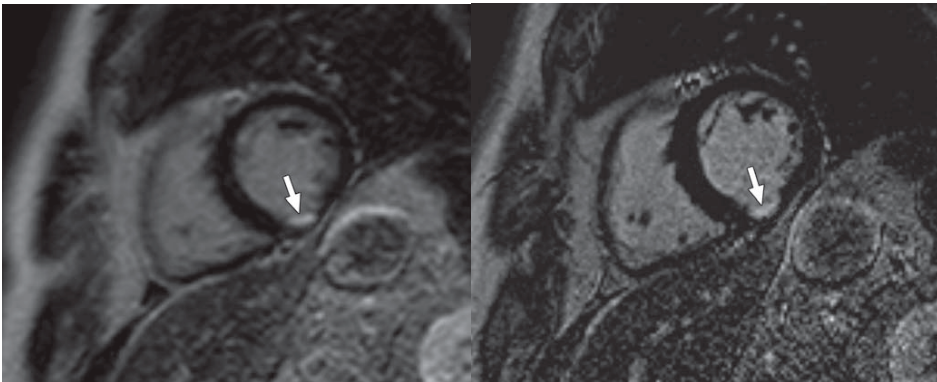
61-year-old man with myocardial infarction in inferior segment after occlusion of right coronary artery. (A) Breath-hold 3D gradient-echo inversion-recovery delayed-enhancement MR image shows myocardial infarction (*arrow*) with hyperintense signal intensity. (B) Free-breathing 2D single-shot inversion-recovery steady-state free precession delayed-enhancement MR image shows myocardial infarction (*arrow*) with hyperintense signal intensity. Both techniques show excellent agreement of maximum transmural extent of hyper-enhancement in relation to thickness of myocardium.
